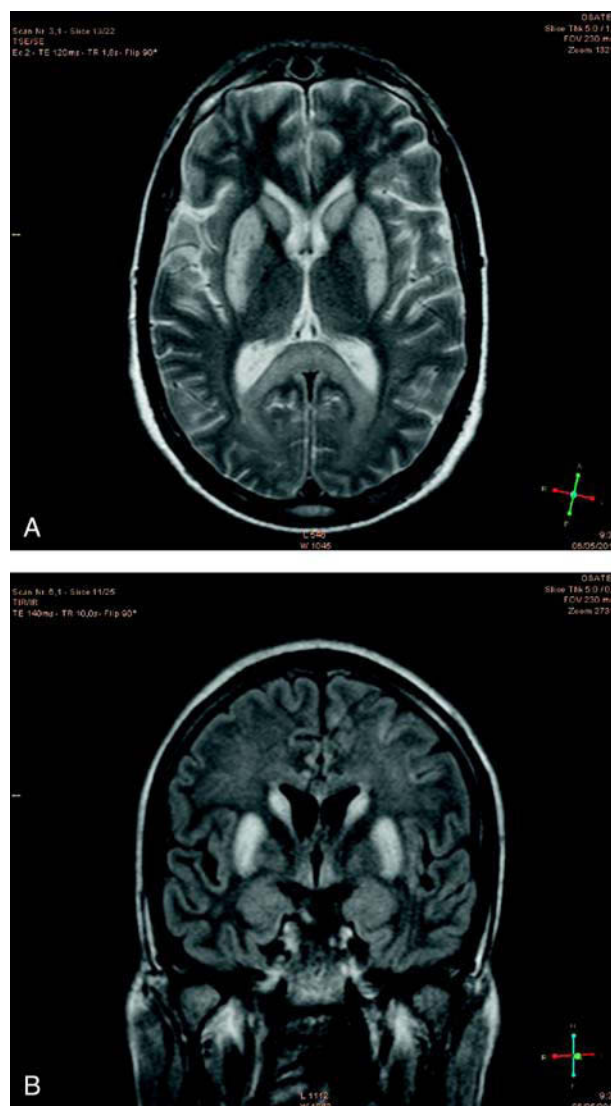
Cranial MRI performed 15 days after admission. A. T2 sequence axial slice; notable hyperintensity on basal nodes and blurring of white and grey matter. B. FLAIR coronal slice; in addition to the hyperintensity on basal nodes and blurring of white and grey matter, widespread gyral swelling is visible giving an image of atrophied sulci.
